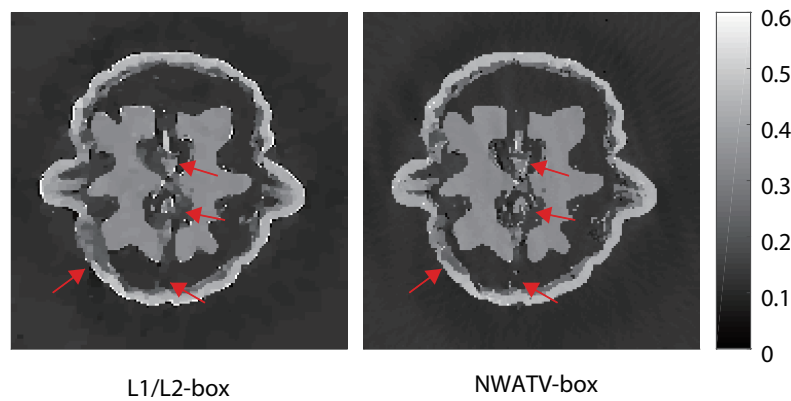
CT reconstruction of walnut. The image size is 164×164 and the grayscale window is $[0,0.6]$. Left: Reconstruction of L_1/L_2 -box. Right: Reconstruction of NWATV-box.
